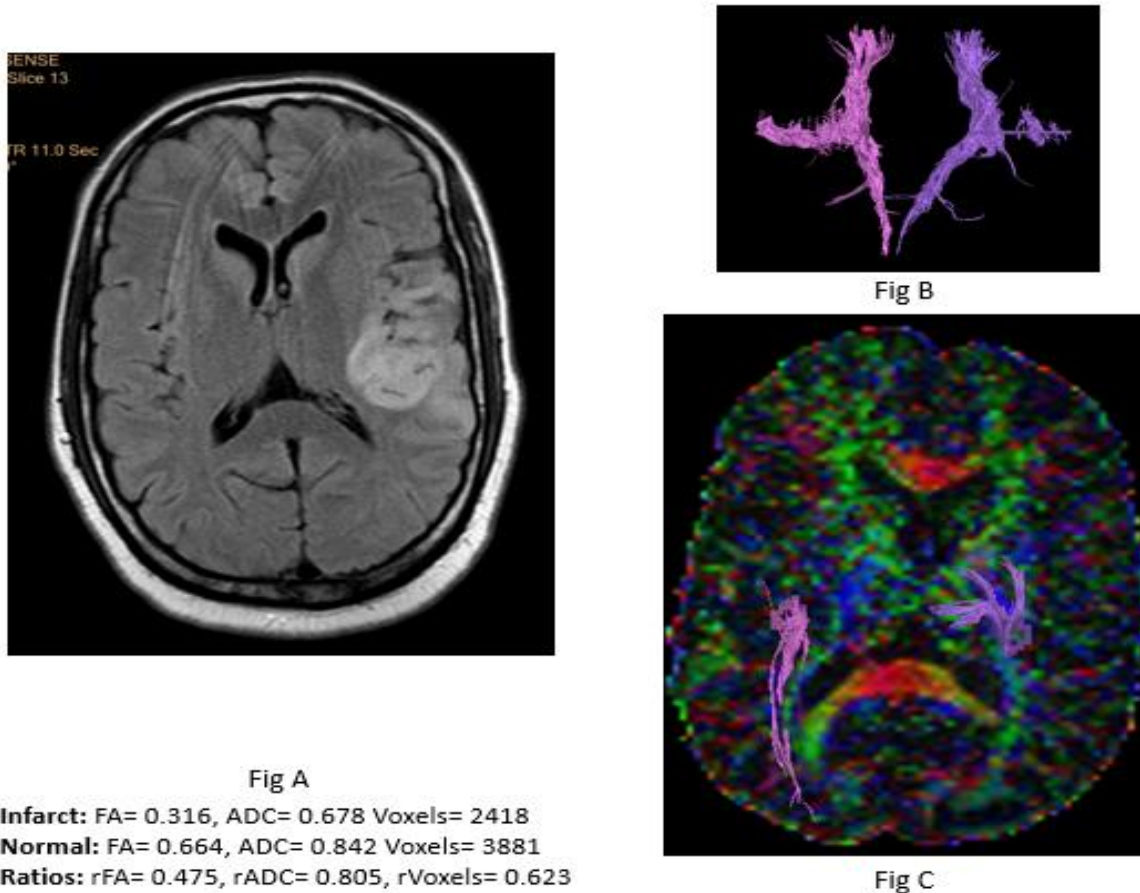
FLAIR axial image shows hyperintensity in the right frontotemporal lobe and insular cortex.
